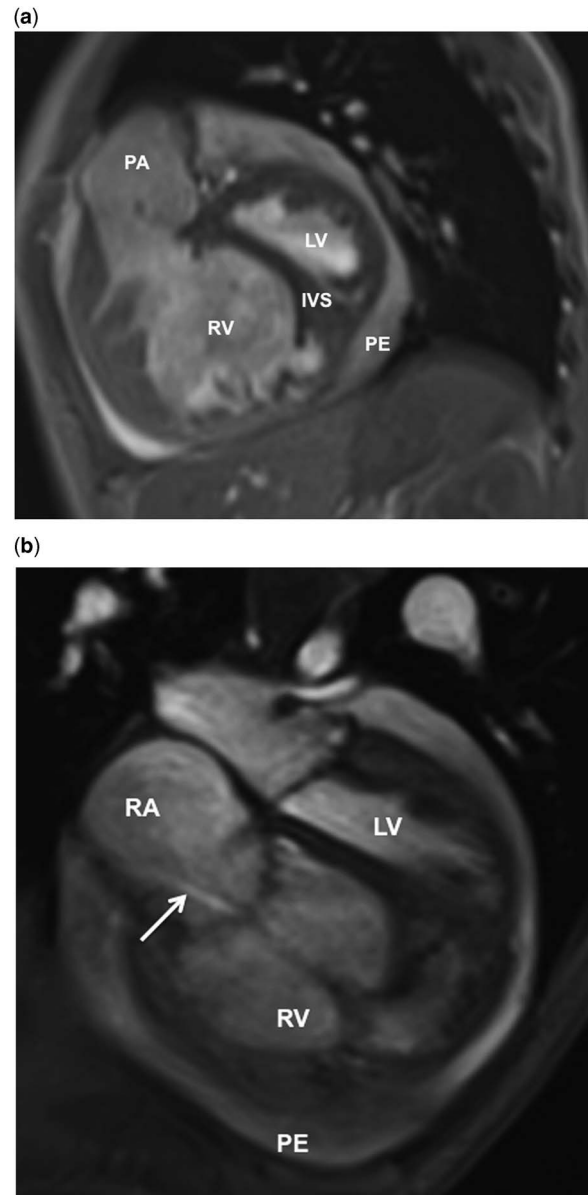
Cardiac magnetic resonance imaging. Short axis (a) and four-chamber view (b) showing the dilated and hypertrophied right ventricle (RV) with enlarged right atrium (RA) and the interventricular septum (IVS) bowing to the left ventricle (LV). Please also note the circular pericardial effusion (PE) and the moderate tricuspid regurgitation (arrow). PA = pulmonary arterial trunk.
